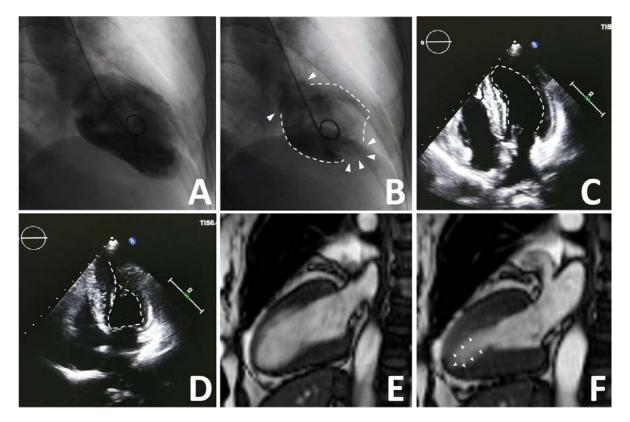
Left ventricular (LV) angiogram of end-diastolic phase (ED) (A) and end-systolic phase (ES) (B). Mid LV akinesia (white dotted line) and basal, apical LV hypokinetic was seen (white line and triangles). A bedside transthoracic echocardiography of ED (C) and ES (D) showed normal motion of LV wall (endocardium was outlined by white dotted line). CMR cine sequence of ED (E) and ES (F) showed hypokinesia of apical LV (F, white triangles)
